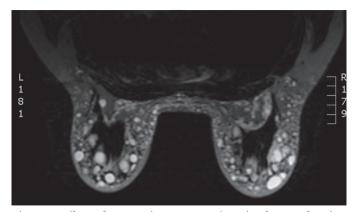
Bilateral magnetic resonance imaging breast showing widespread silicone granulomata.
